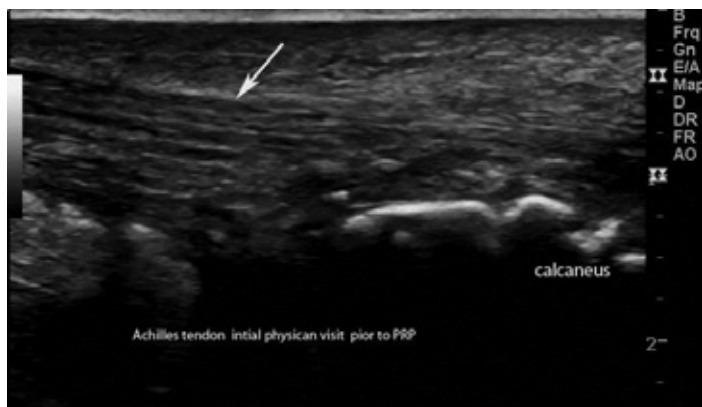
Sonogram taken at initial presentation.
